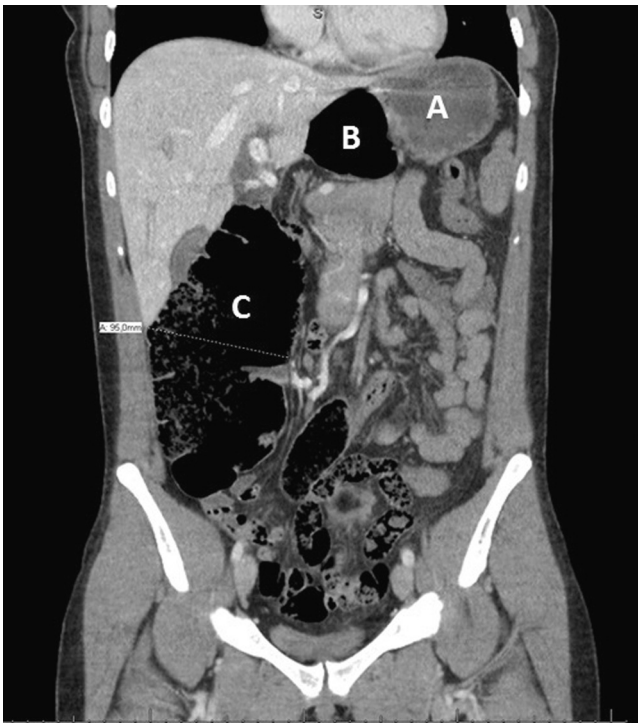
Coronal image of the computed tomography scan showing a dilated ascending colon with a herniation of the hepatic flexure between liver and stomach. (A) Stomach. (B) Omental bursa with herniated and distended colon loop. (C) Distended ascending colon.
